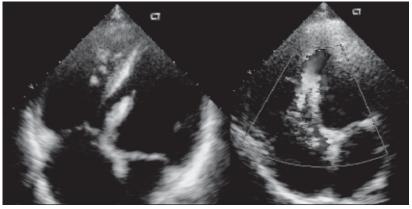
Apical 4-chamber view showing oblique muscular VSD and dilated RA and RV (2-D image-left) and CFM showing left to right shunt with TR (right).
